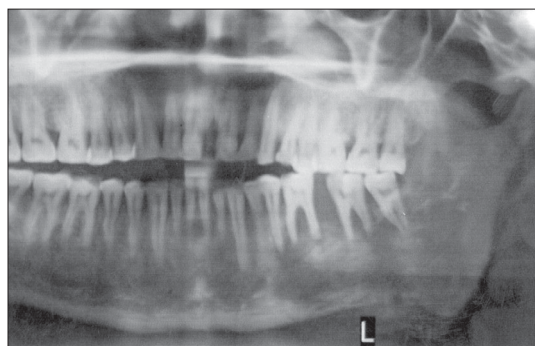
Showing radiograph of displacement of teeth, superficial erosion of the buccal cortical plate and root resorption associated with the posterior teeth on the left side of the mandibular arch
